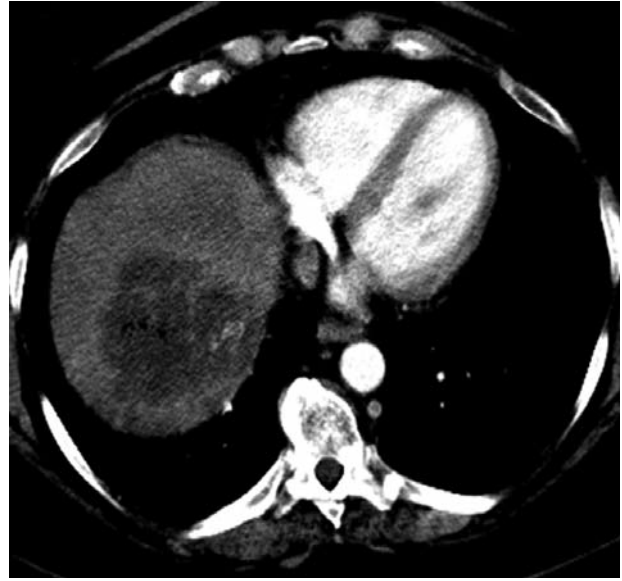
Triple-phase computed tomographic scan post-DEBIRI treatment.
